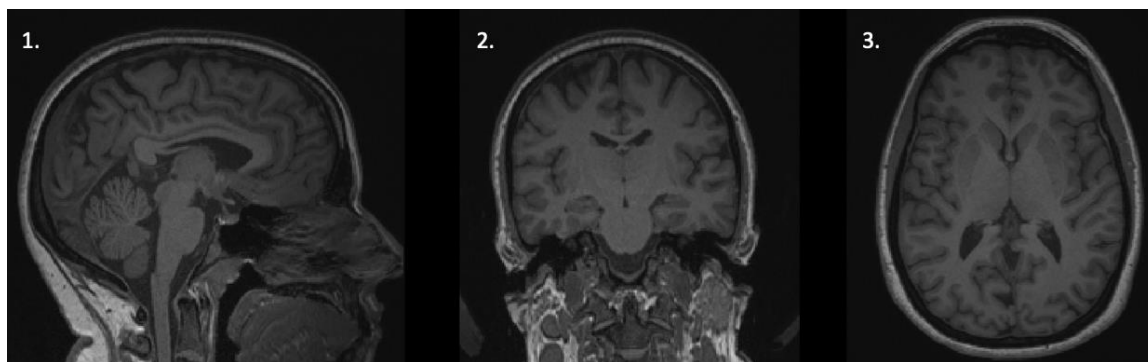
T1-weighted structural imaging. Different views are presented: 1) sagittal, 2) coronal, 3) axial. WM is bright, GM is darker.
